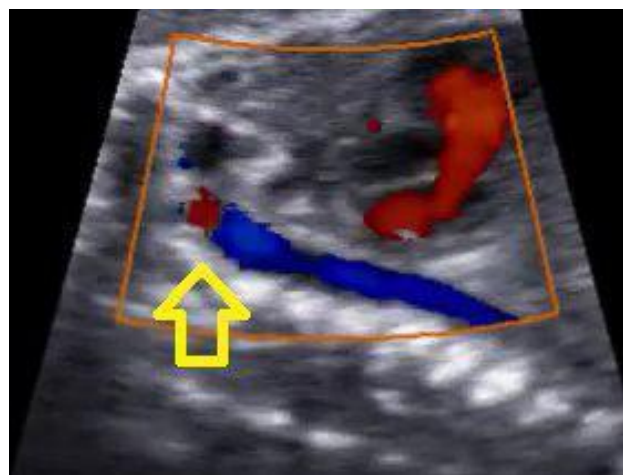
Aortic arch view in fetal echocardiography showed antegrade and retrograde flow in DAO proximal.
